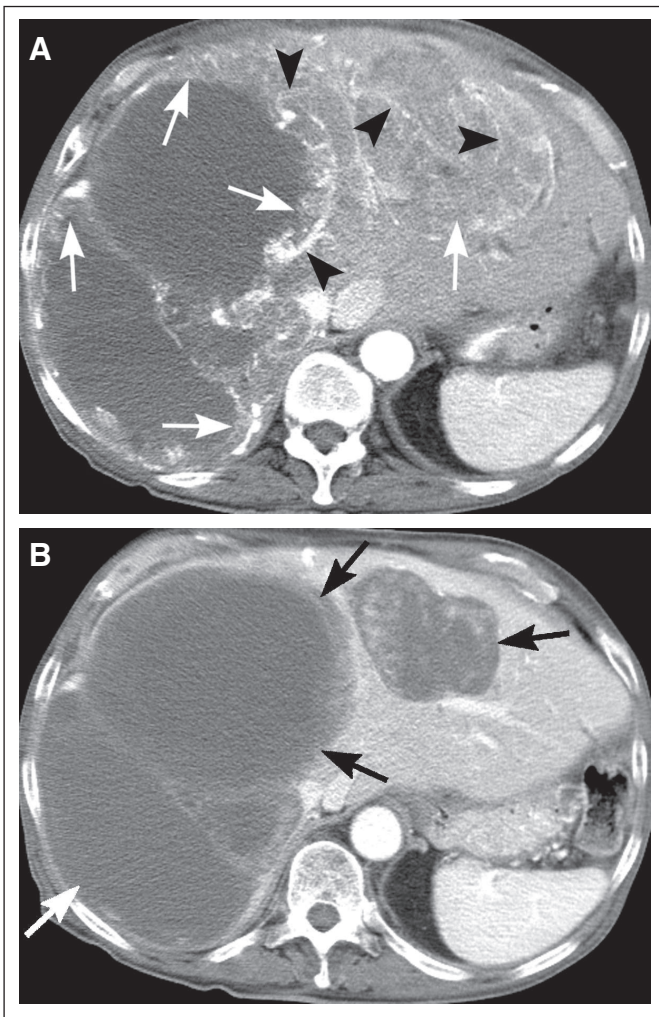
A 77-year-old man with primary gastrointestinal stromal tumors of the stomach and multiple hepatic metastases. (A) Pretreatment computed tomography (CT) scan shows large hepatic masses on a late arterial-phase image with hyperdense tumor nodules (→) along the periphery. Note the multiple prominent tumor vessels (arrowheads). (B) CT scan obtained 2 months after treatment shows that the lesions (→) have become significantly hypodense. The enhancing tumor nodules have almost completely disappeared and tumor vessels are no longer detectable.
